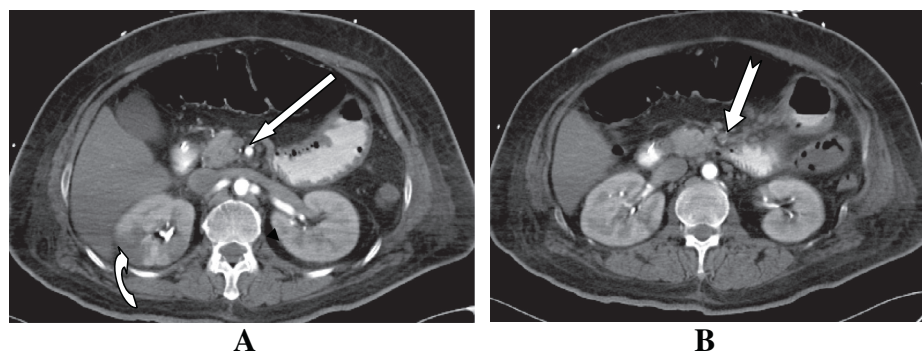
Arterial phase contrast enhanced CT scan abdomen shows: (A) Normal filling of the celiac artery (arrow) and (B) lack of filling of the thrombosed superior mesenteric artery (notched arrow). Right renal cortical infarct is seen as well (curved arrow in A).
